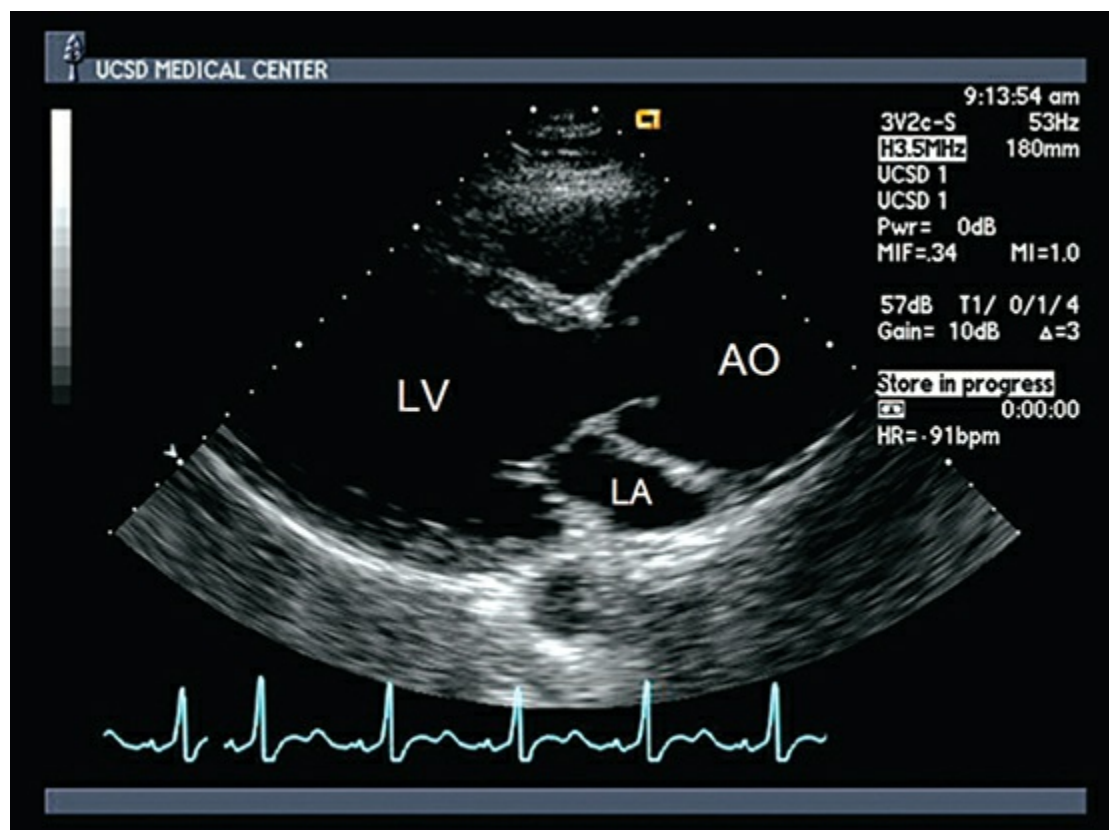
Parasternal long-axis view. AO, Aorta; LA, left atrium; LV, left ventricle.
